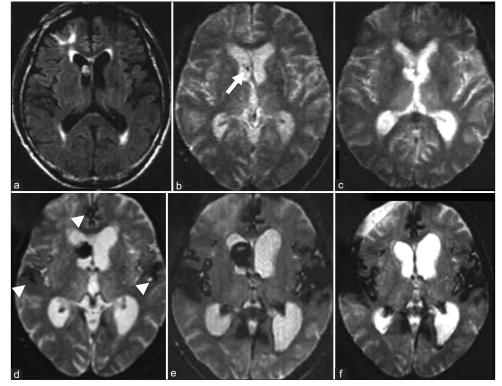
Magnetic resonance imaging (MRI) findings. Initial fluid-attenuated inversion recovery MRI showing an intraventricular tumor (a). Initial T2-star weighted MRI (T2*WI) also revealed a tiny low-intensity spot (arrow), suggesting intratumoral hemorrhage 7 years before surgery (b). Note that 5 years before surgery, this signal change was localized within the tumor and not on the brain surface (c). Low intensity suggesting intratumoral hemorrhage and superficial siderosis on the brain surface (arrowhead) is demonstrated on T2*WI 3 years before surgery and ventricular enlargement progresses (d), and is exacerbated immediately before surgery (e). Hemosiderin deposition and hydrocephalus persisted even after tumor removal (f).
